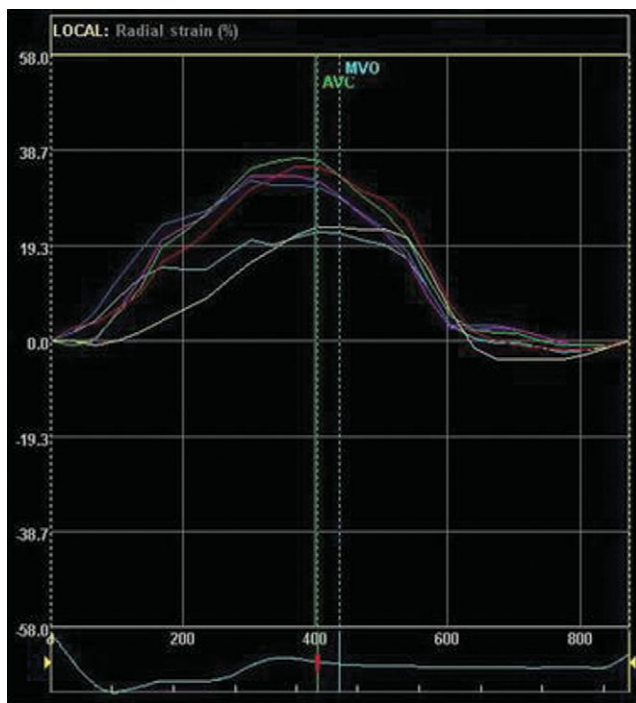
Radial strain tracings for one cardiac cycle obtained from the parasternal short-axis view in the patient with akinesia of the septal wall. There are six tracings for the six evaluated segments within the circumference. The SR tracing of the septal segment demonstrates a low peak systolic radial strain compared with the other segments.
